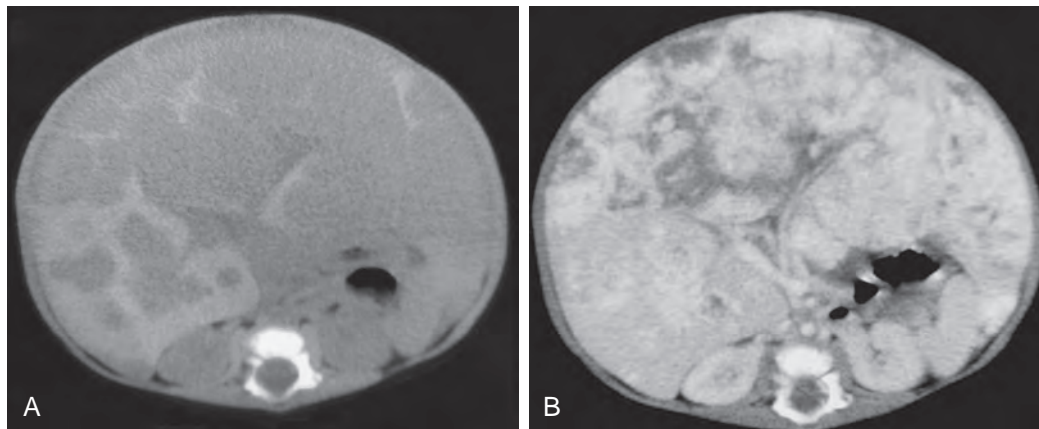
Multifocal hemangioendothelioma of the liver in a 2-week-old girl who presented with hepatomegaly. A. Noncontrast CT of the abdomen demonstrates multiple, low-attenuation lesions within both lobes of the liver. B. After the intravenous administration of contrast material, there is dense peripheral enhancement of these lesions.
